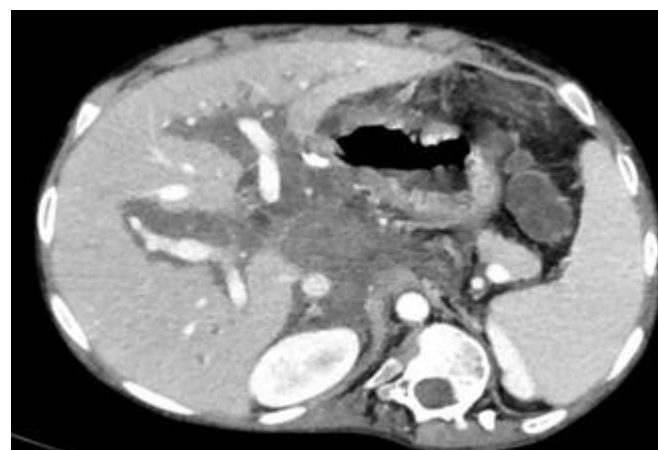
Abdominal contrast-enhanced computed tomography (CT) revealed a huge coeliac mass that not involved adjacent organs and vessels.
